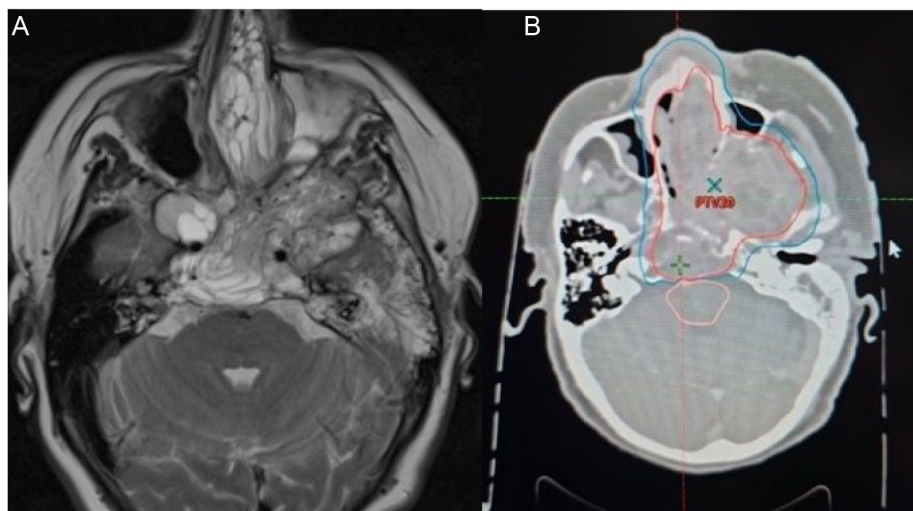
Magnetic resonance imaging of the head showed relapse of tumor (A). Computed tomography of the head from radiotherapy (B).
